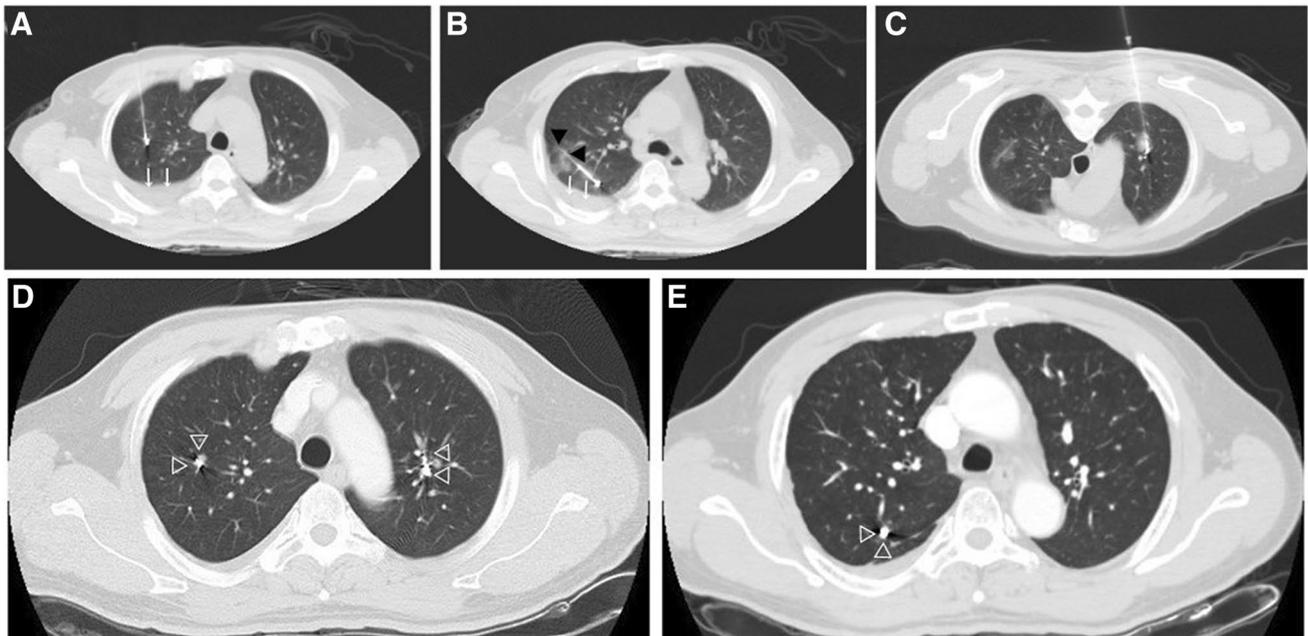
Computed tomography (CT)-guided percutaneous ^{125}I seed implantation was performed. a, b Two applicators were inserted into the tumor in the right lung to implant ^{125}I seeds. A small amount of pulmonary hemorrhage (black arrows) and pleural effusion marked
